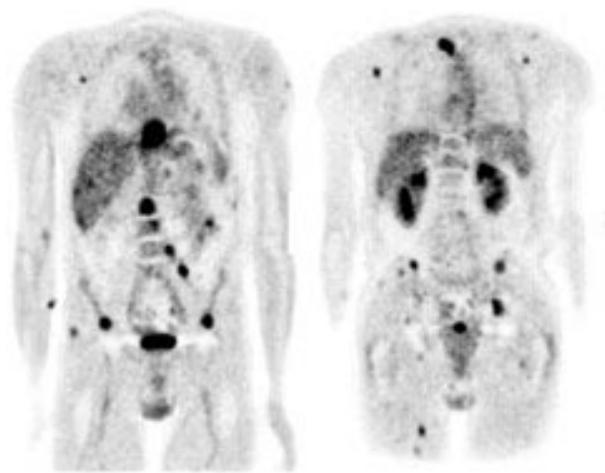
A 57 year old man with oesophageal cancer and clinical stage T3N1 presented for staging evaluation. (Left) Anterior coronal and (right) posterior coronal FDG PET show multiple foci of intense metabolic activity compatible with widespread metastases. CT scan confirmed many of these sites, but was unable to detect spread to lymph nodes and distant soft tissue site.
